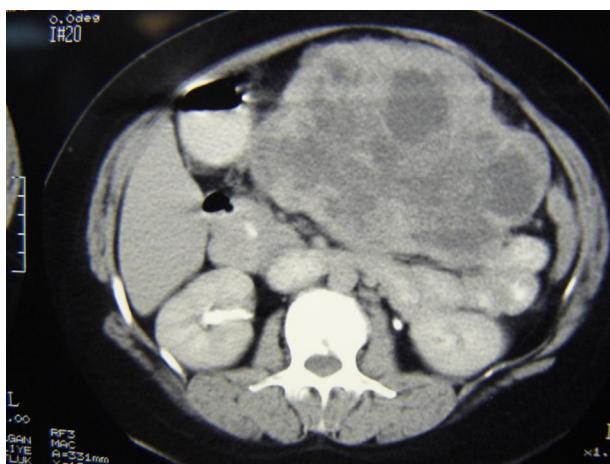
Abdominal computed tomography scan revealing the mass located between gastric posterior wall and the pancreas.
